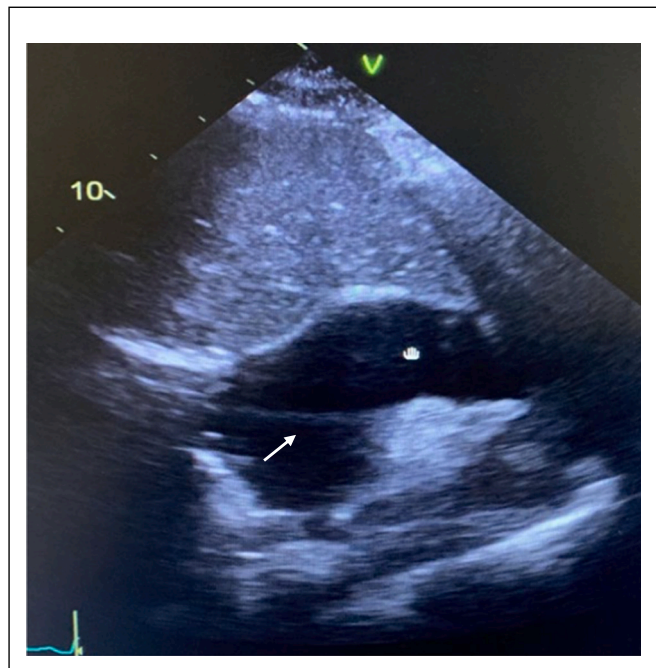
Transthoracic echocardiogram subcostal view. Note the large pericardial effusion (hand pointer) with a pericardial septum (white arrow).
